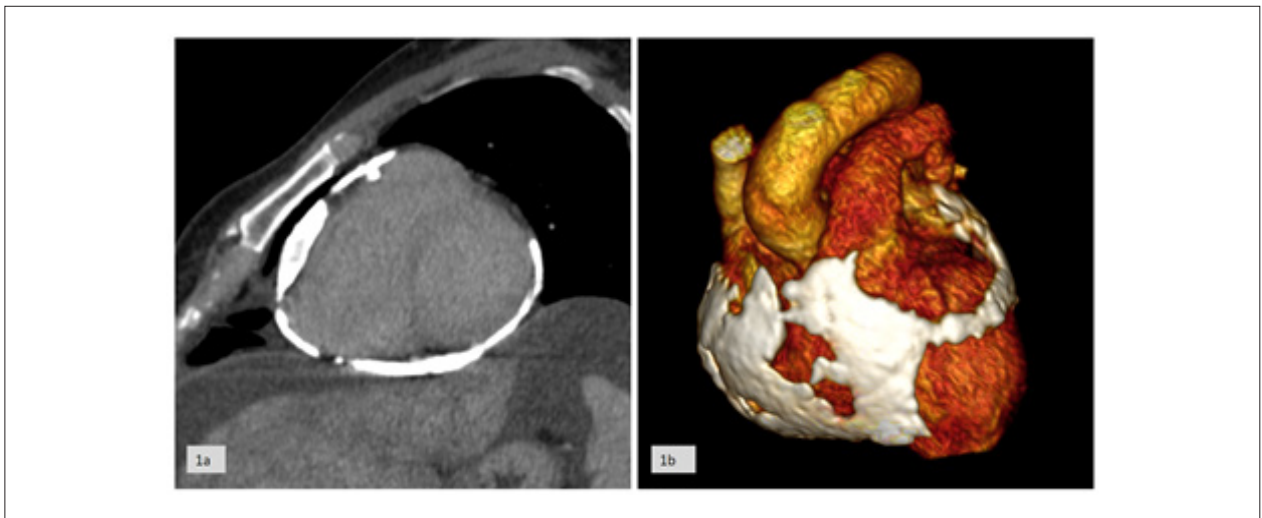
1a) Computed Tomography of the heart with calcified pericardium. 1b) 3D rendering of the tomographic image of the heart with calcified pericardium.
